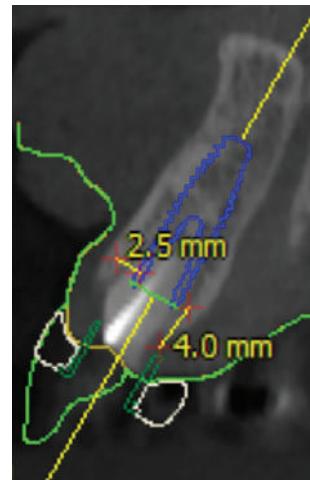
Digital measurements can be made on computed tomography images.
